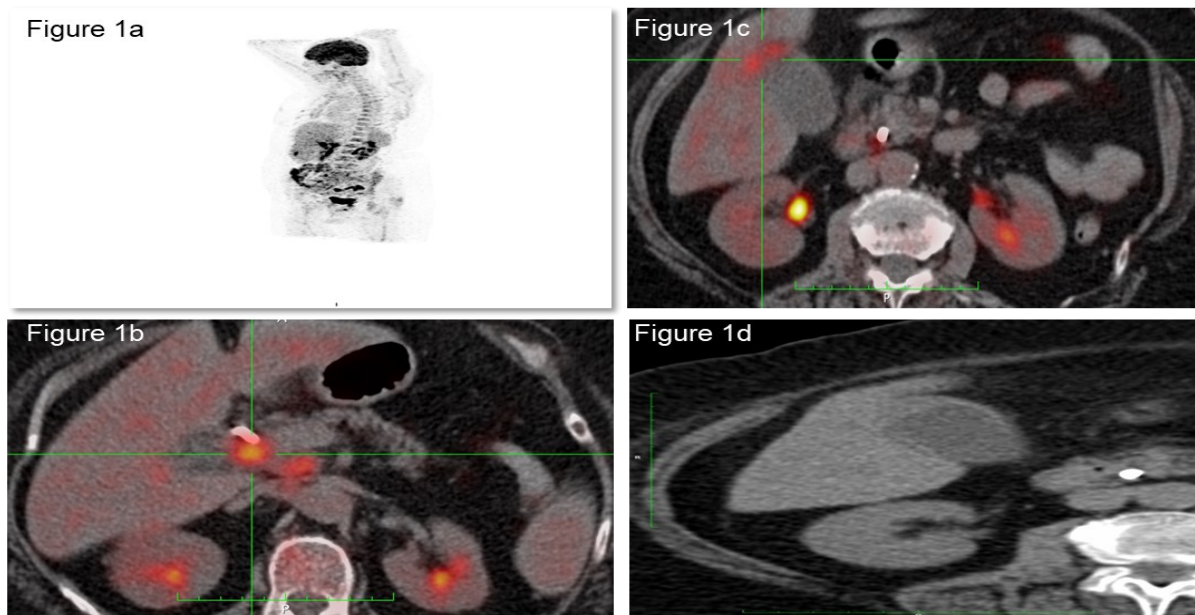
A 64-year-old woman, who had the complaint of jaundice, was referred for FDG PET-CT. Maximum intensity projection images (a) of the patient revealed hypermetabolic lesions around the pancreas head as
